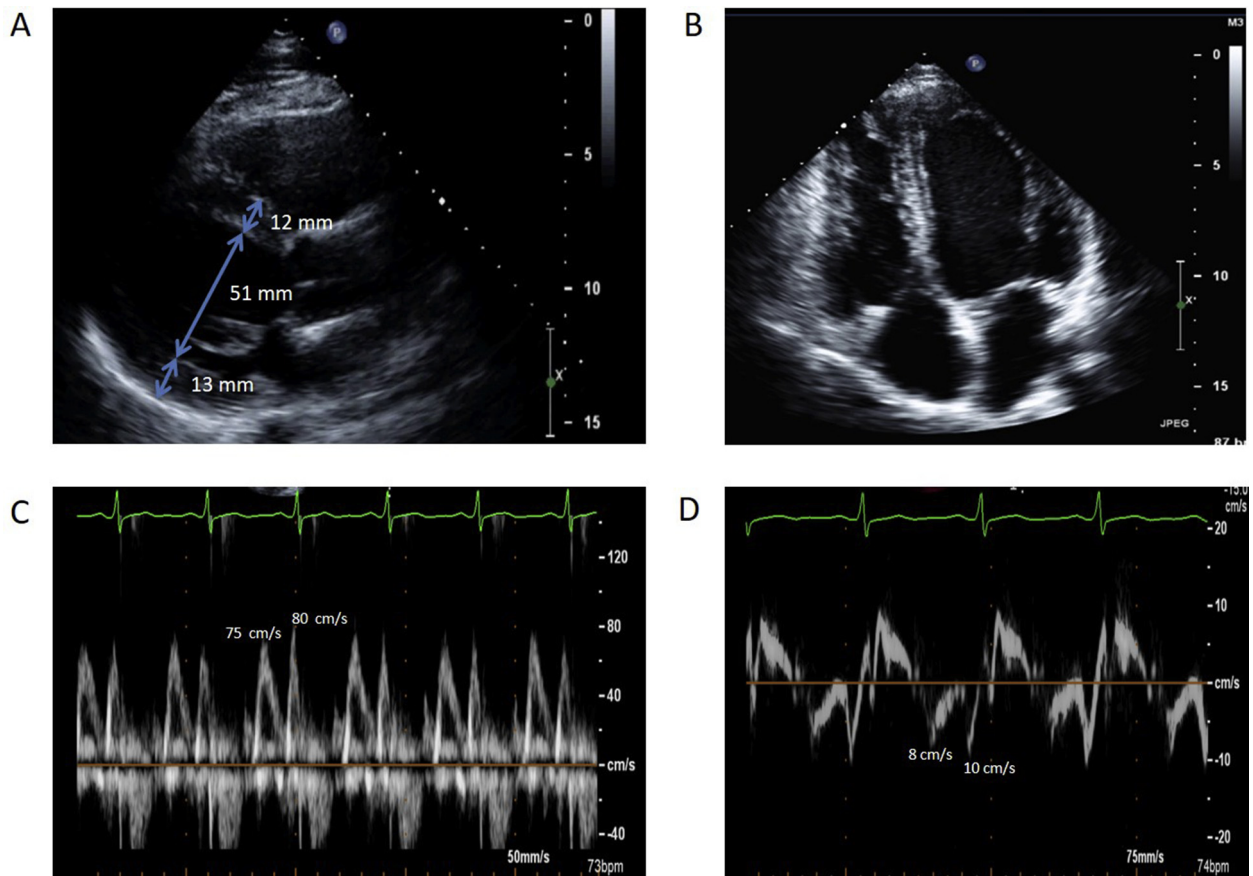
Representative transthoracic echocardiographic imaging from a healthy asymptomatic competitive strength-sport athlete. (A) Parasternal long-axis view demonstrating concentric left ventricular hypertrophy as manifested by left ventricular wall thickening in the absence of chamber dilation. (B) Apical 4-chamber view demonstrating left greater than right ventricular end-diastolic areas. (C) Trans-mitral pulsed-wave Doppler imaging showing E/A ratio ~ 1.0 . (D) Tissue Doppler imaging of the lateral mitral annulus showing mild reductions in early diastolic relaxation velocities ($e' \sim 8$ cm/s) and a' prominence.
